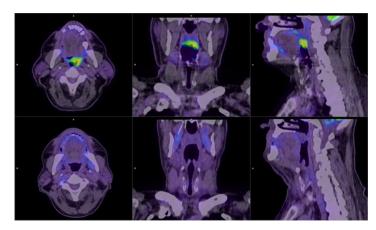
Complete remission (CR): (upper-line) axial, coronal and sagittal PET/CT images show the mesopharynx tumor spreaded over the midline, pre-treatment SUVmax:6,3. Post-treatment (lower-line) axial, coronal and sagittal PET/CT images show Complete Remission (CR); without any pathologic 18-F-FDG accumulation on the observed volume.
